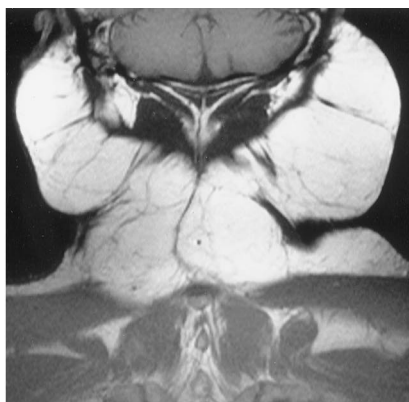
Coronal T1-weighted MR image (500/20) shows excess fat in the neck posteriorly and laterally. Although fat is present posteriorly, the site of maximum deposition is in the soft tissues laterally.
